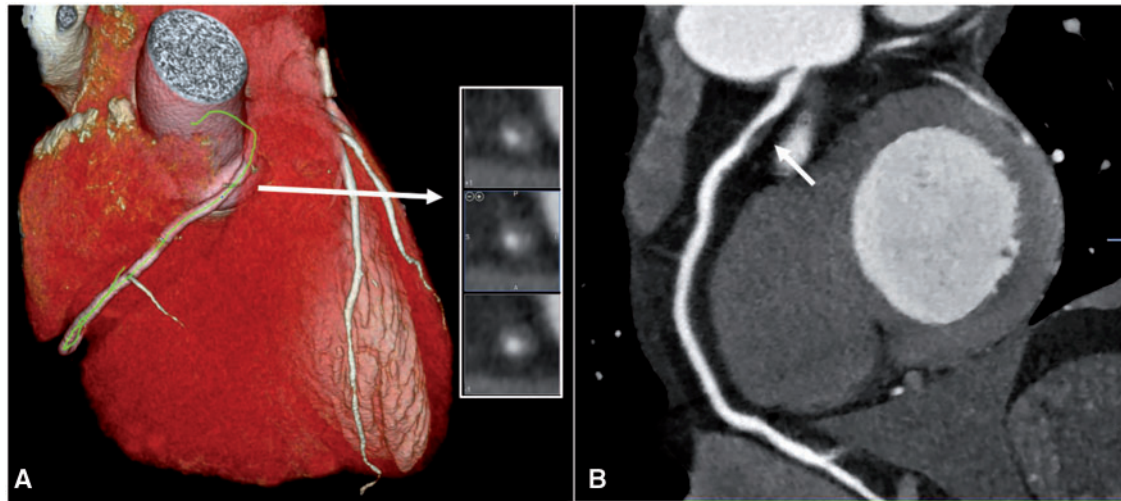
Ultralow-dose coronary CTA performed in a 67-year-old female (BMI 20) with a 320-row multidetector CT scanner, using a single heart-beat acquisition technique. By combining an 80-kVp tube voltage with third-generation iterative reconstructions, a sub-mSv radiation dose was obtained (0.7 mSv) with a high diagnostic quality of the examination. Volume rendering (A) and curved planar reconstruction (B) images show the presence of a high-risk, eccentric, soft tissue lesion in the proximal right coronary artery causing a high-grade stenosis.
